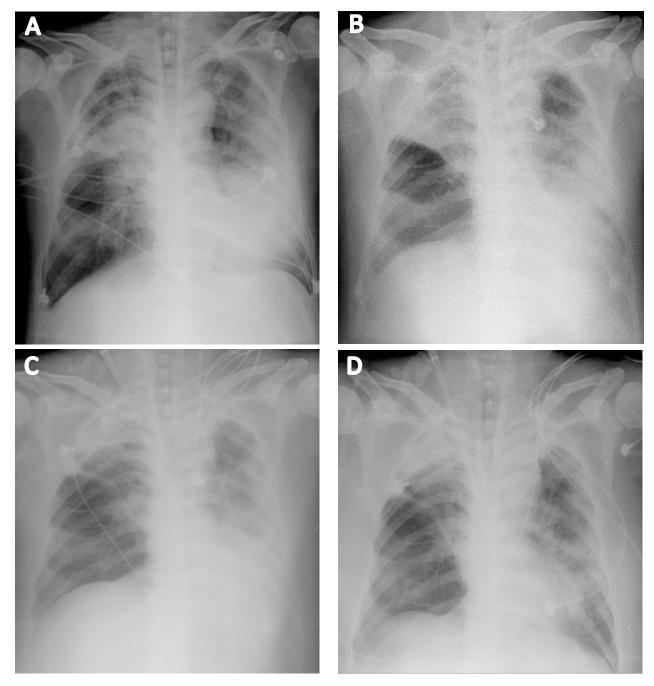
Chest X-ray over the days of illness. (A) chest X-ray showed infiltration when admitted (day 3). (B) peramivir 100 mg QD (day 13). (C) peramivir 200 mg QD (day 18). Mixed infiltration and pulmonary consolidations were noted after peramivir treatment. Considering CVVH application might lead to excessive clearance of peramivir, dose titration was applied on the patient. Less infiltration was noted. (D) favipiravir (day 24). Favipiravir was prescribed for the patient under the suggestion from CDC due to resistant strain of H7N9 was isolated. Lung function has been improved after 5 days course.
